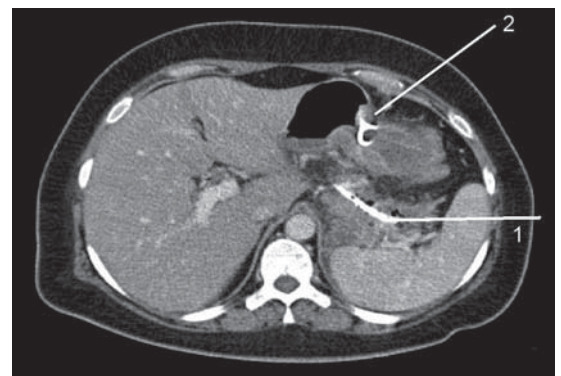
CT scan with percutaneous (1) and transgastric (2) drainage. High-volume lavage was directed from the percutaneous to the endoscopically placed catheter.
